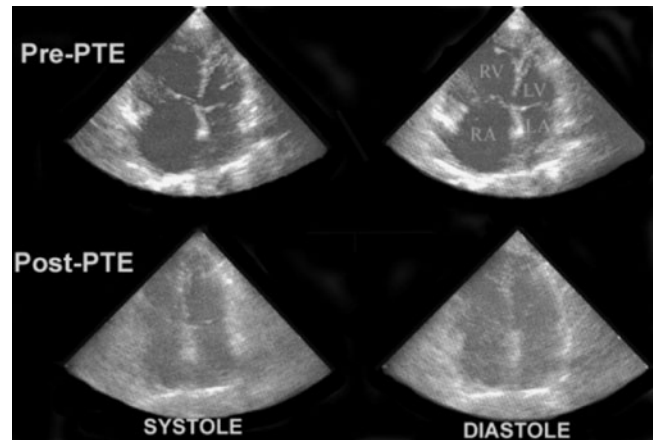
Appearance of echocardiography before and after the operation. The top images represent pre-PTE and the bottom images represent post-PTE. Note the shift of the intraventricular septum toward the left in the systole before the operation, together with the relatively small left atrial and left ventricular chambers. After the operation, the septum has normalized, and the right-sided chambers are no longer massively enlarged. LA = left atrium; LV = left ventricle; PTE = pulmonary thromboendarterectomy; RA = right atrium; RV = right ventricle.
